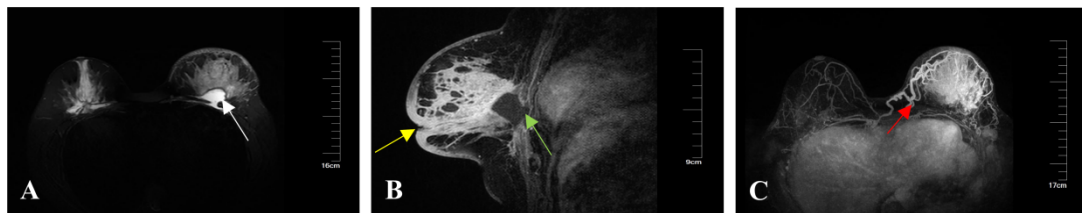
MRI images. (A) Axial T2-weighted images showing PAAG granules with hyperintensity (white arrow), (B) Enhanced sagittal T1-weighted images showing nipple retraction, skin thickening, peripheral edema (yellow arrow), and partial defect of the pectoralis major muscle (green arrow), (C) Enlarged and circuitous blood vessels around the lesions (red arrow).
